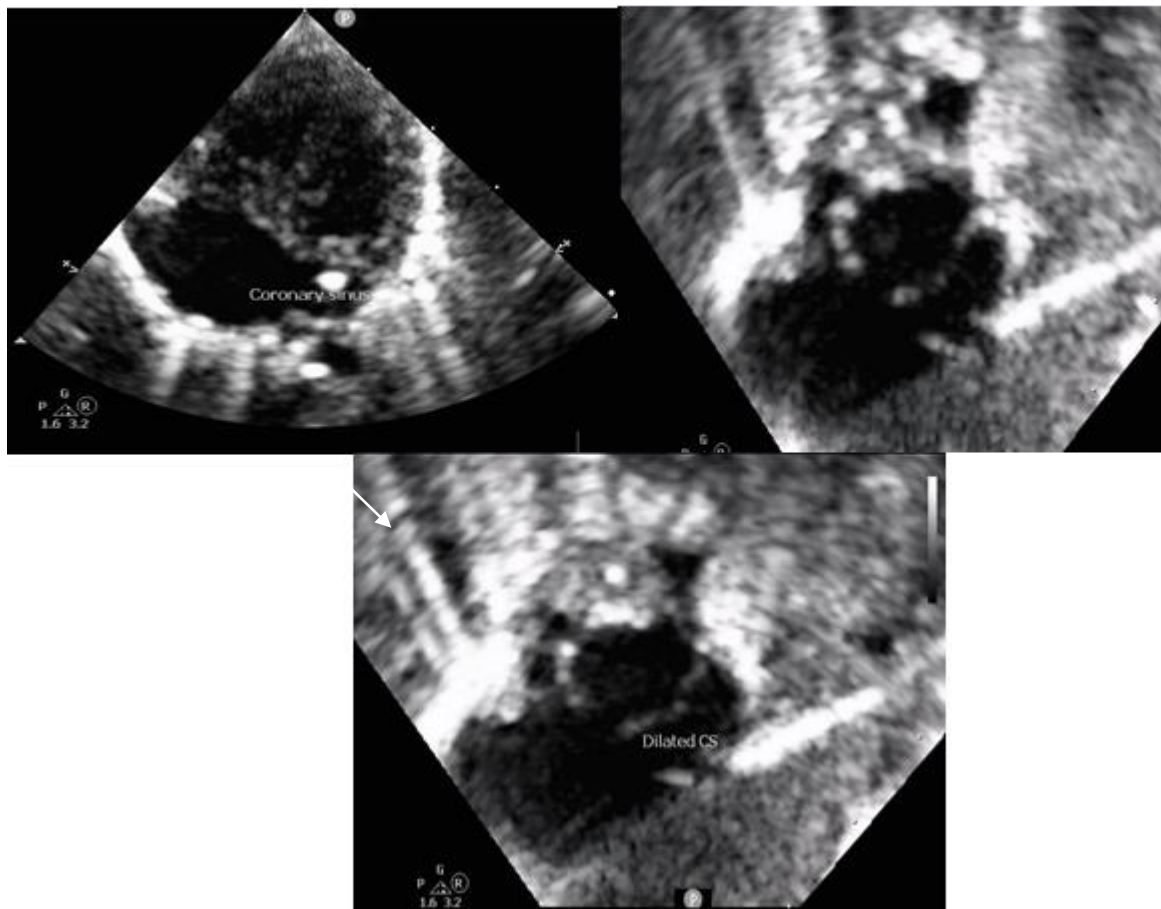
Echocardiograph, Subxiphoid short axis (sagittal) bicaval views showing dilated coronary sinus.
